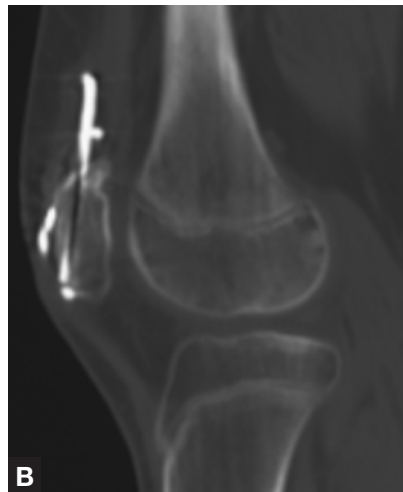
Case 1—Computed tomography (CT) scan 6 months after injury confirmed lack of displacement and satisfactory healing of the femur fracture.
